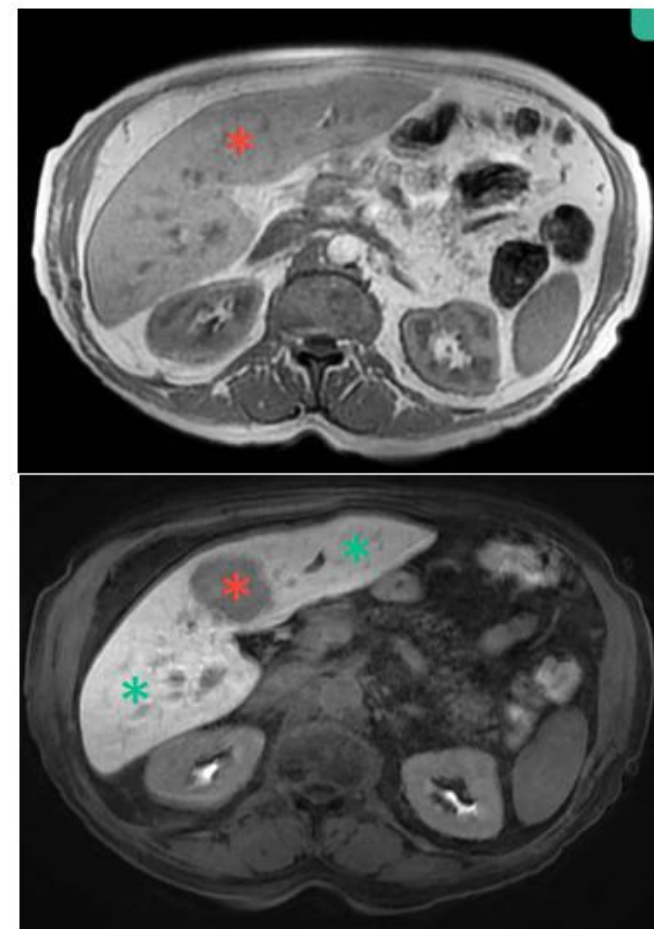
Liver MRI pre and 20 min post iv administration of Gd-EOB-DTPA with no uptake in an adenoma (red asterisk) and contrast agent uptake in normal liver tissue (green asterisk).
